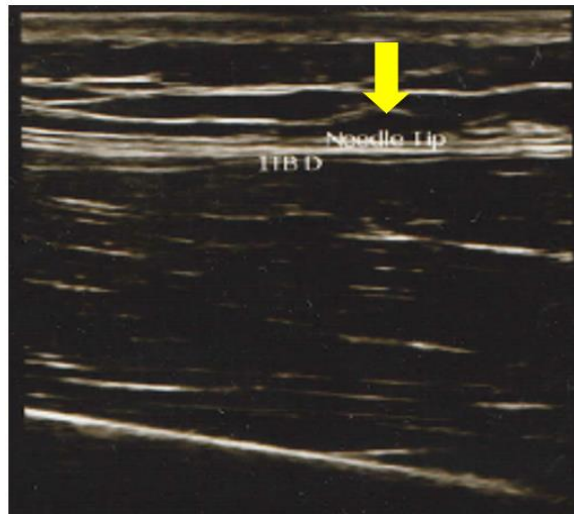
Position of steroid injection against ITB guided by *Ultrasonography* (USG)
